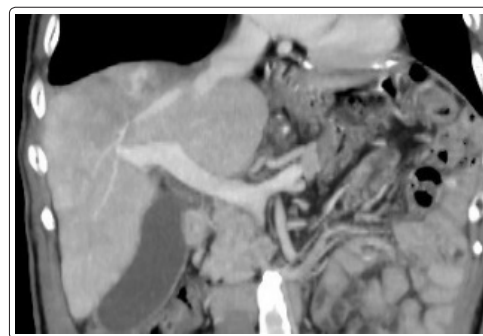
Contrast-enhanced axial CT images at 16 months post-90Y-TARE indicate complete mass retraction from the RA.
